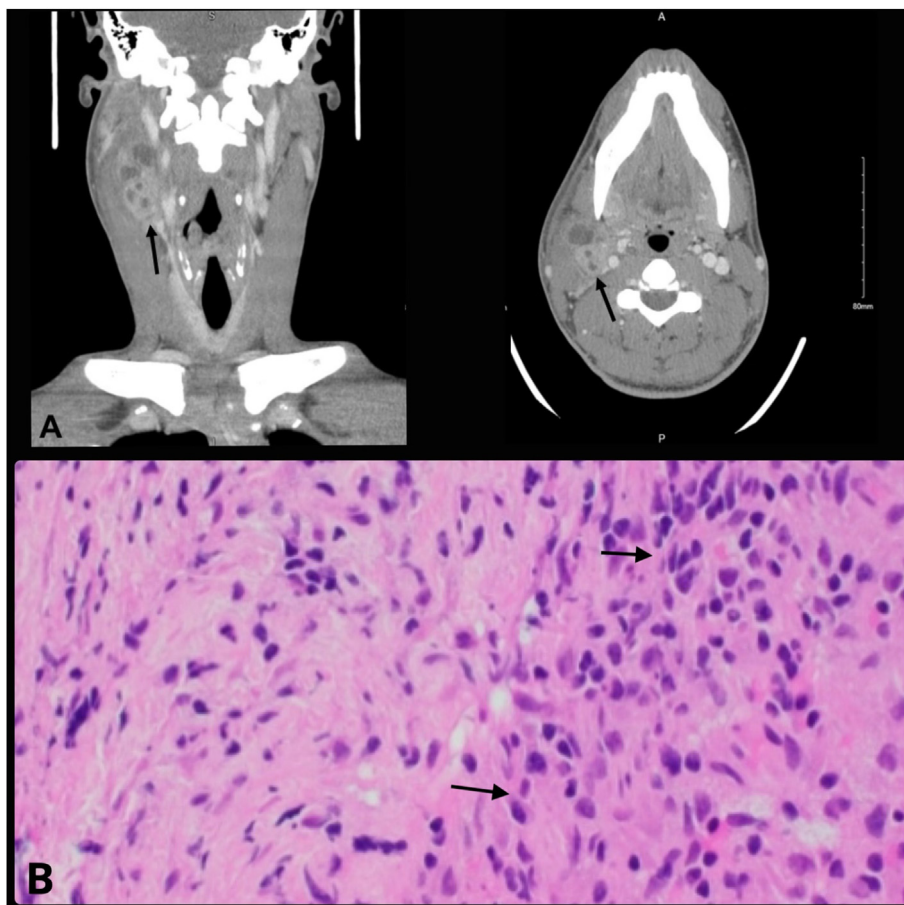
A Frontal and Axial planes of CT Neck images demonstrate the  $4.3 \times 2.1 \times 2.9$  cm right cervical heterogenous lymph node with areas of necrosis throughout. B Mixed inflammatory cells with a predominance of lymphocytes mixed with neutrophils, plasma cells and macrophages with poorly formed granulation tissue in addition to areas of necrosis, overall suggestive of granulomatous lymphadenitis with necrosis.
